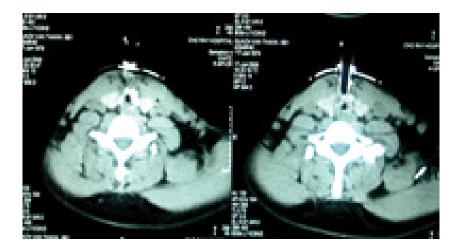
CT-scan laryngeal stenosis
